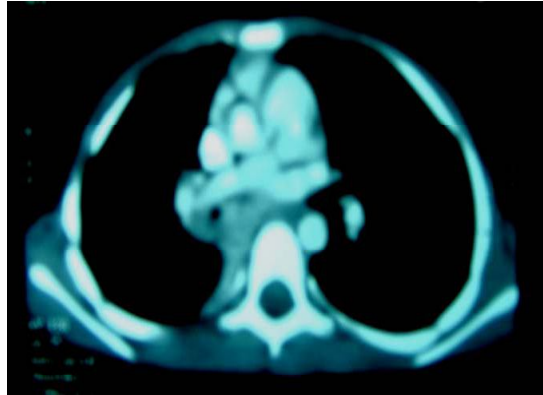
Post contrast CT showing a very narrowed bronchial residual lumen with paraspinal lung collapse.
